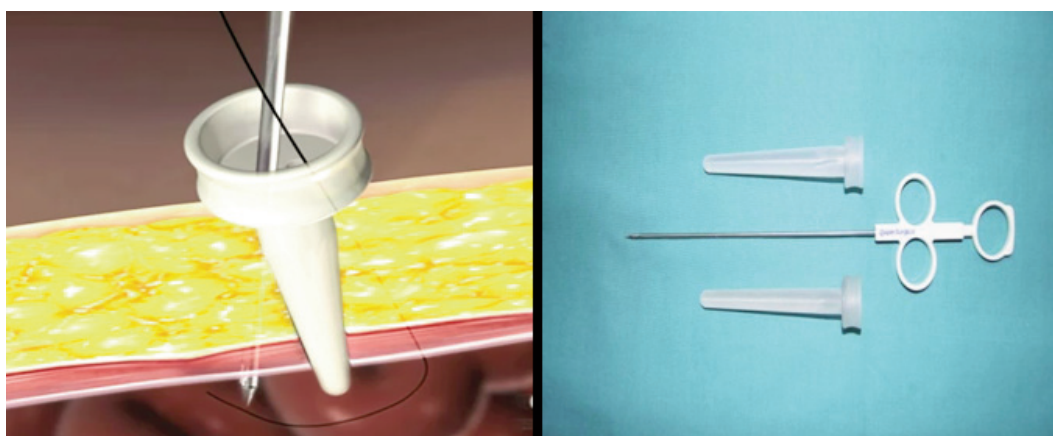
Fascial suturing with Carter-ThomasonClose Sure System® - Cooper Surgical Inc., Trumbull CT USA.
